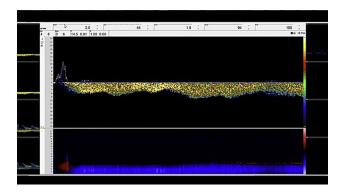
Visual graphic display of the corresponding positive Doppler waves. The y-axis denotes the speed of blood flow (cm/s), and the x-axis denotes time (seconds).
